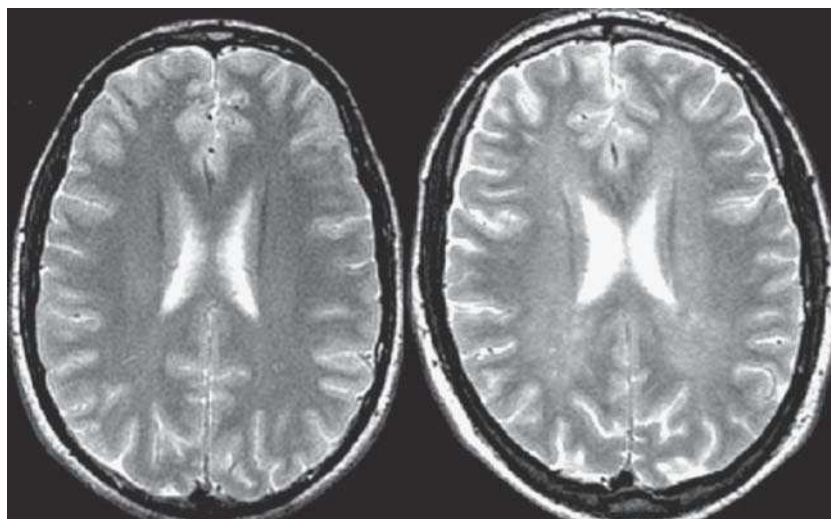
Brain magnetic resonance imaging. Transverse T2-weighted sequences in a healthy subject (left) and in a patient with multiple sclerosis (MS) (right). Note the discrete diffuse hypersignal shown by the hemispheric white matter in the patient with MS (dirty-appearing white matter).
